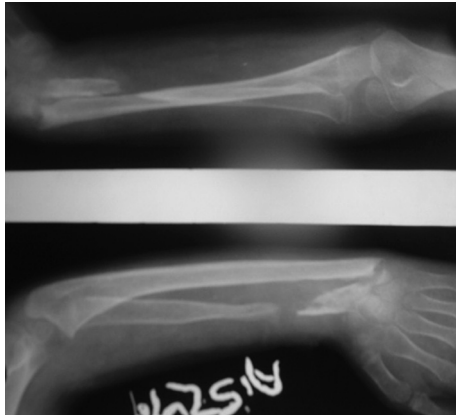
Radiograph showing gap nonunion of the distal radius, with radial deviation of the wrist and hand.
